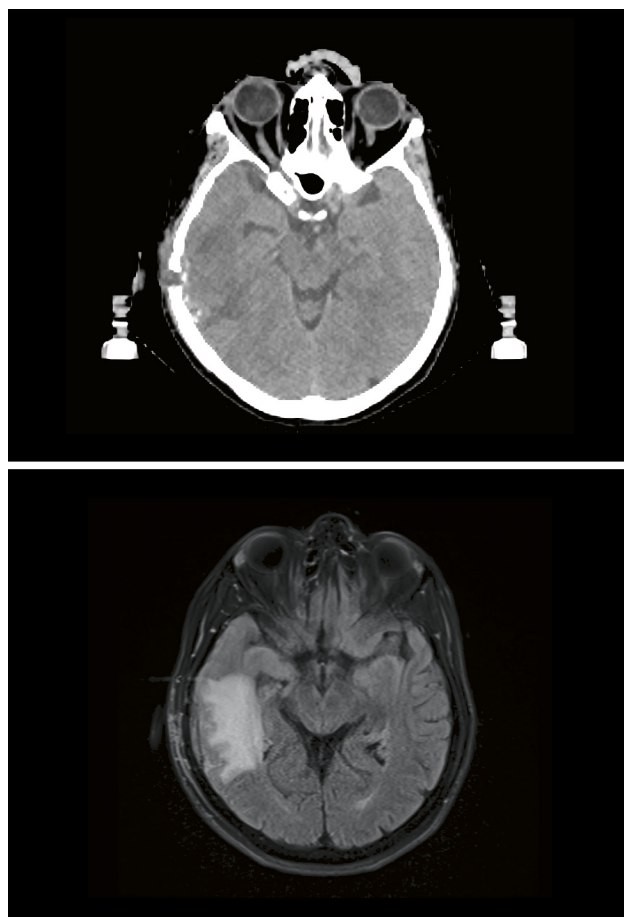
Left image: CT, right image: MRI (T2 flair)
